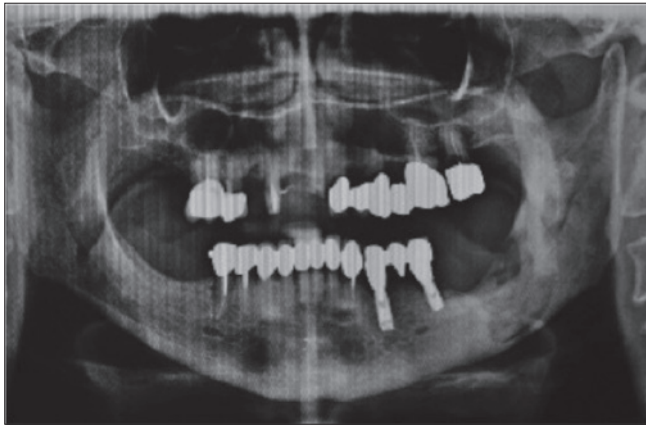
Panoramic radiograph reveals wide bone destruction in the left mandibular angle, with residual height less than 6 mm.
